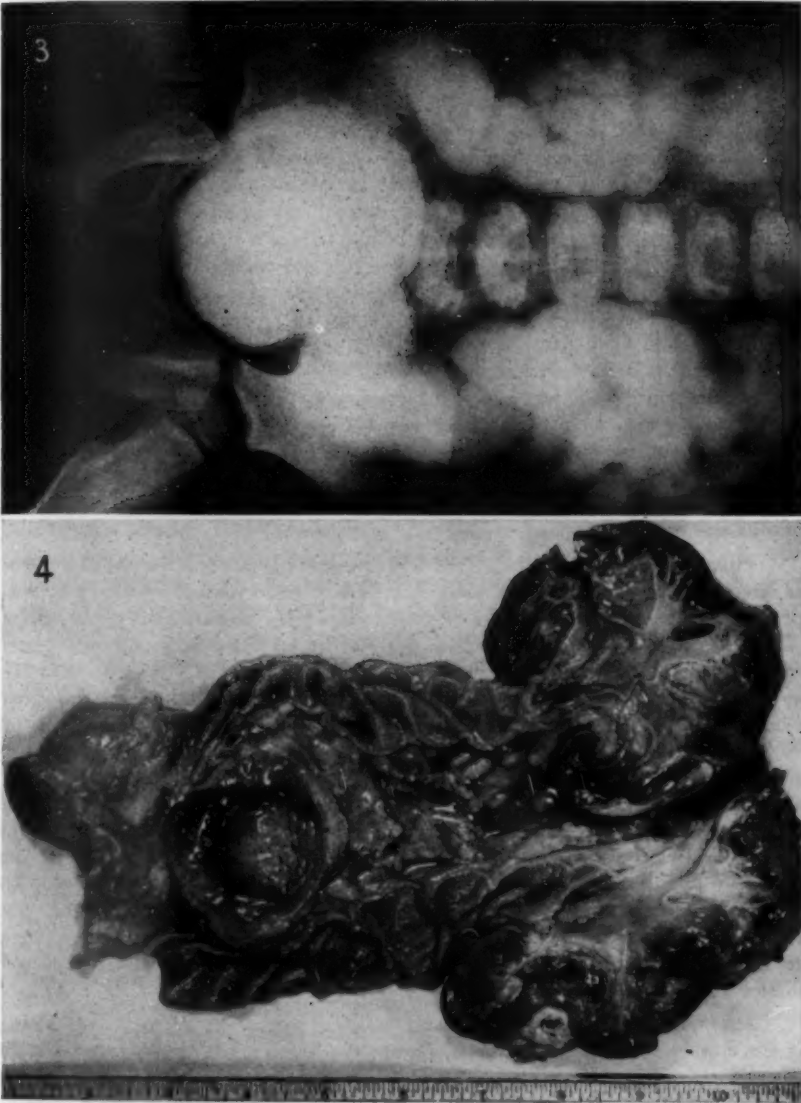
(case 2).—Roentgenogram showing filling of the upper part of the urinary tract by a contrast medium injected into the bladder.
